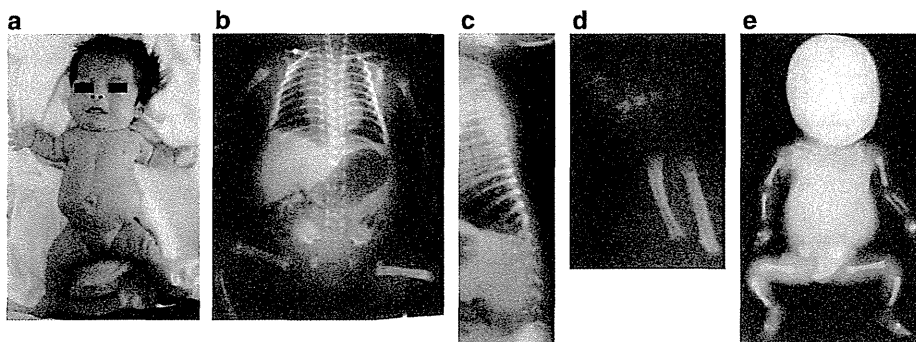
Phenotype of patients in Family 1. (a) Appearance of the proband in Family 1. Rhizomelic micromelia, frontal bossing, flat nasal bridge, low set ears, anteverted nostrils, micrognathia, narrow thorax and distended abdomen were noted. Radiographs of the proband (II-1) at birth (b–d) and the aborted fetus (II-2) (e). Characteristics of opsismodysplasia including retarded bone maturation, shortness of the bones of hands and feet, concave metaphyses and thin, lamellar vertebral bodies were noted.
